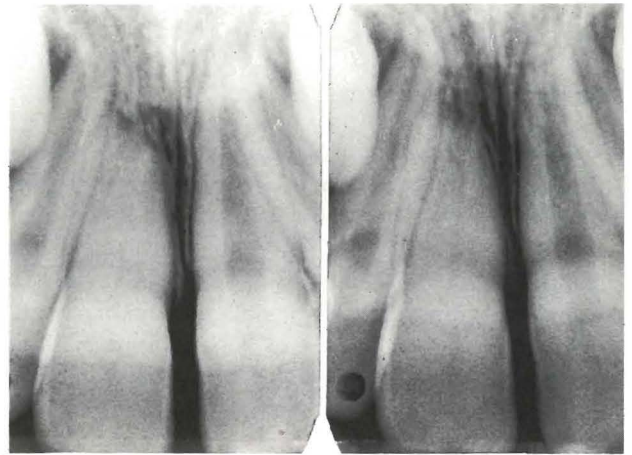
A nine-year-old girl had an accident when she was six years old. The radiograph on the left shows obliteration of the pulpal canal with a short root of the maxillary permanent right central incisor (11). The radiograph on the right shows the situation a year later.
